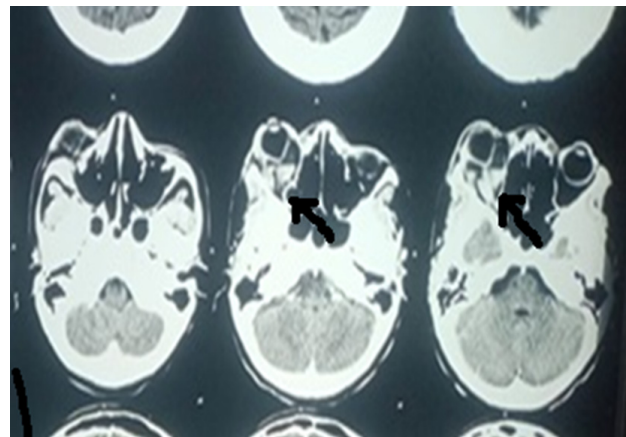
Axial CT cuts showing retrobulbar right eye hyperdense opacities causing proptosis and no intracranial lesions (arrowheads). (© Dr. Lydia Muoki)
